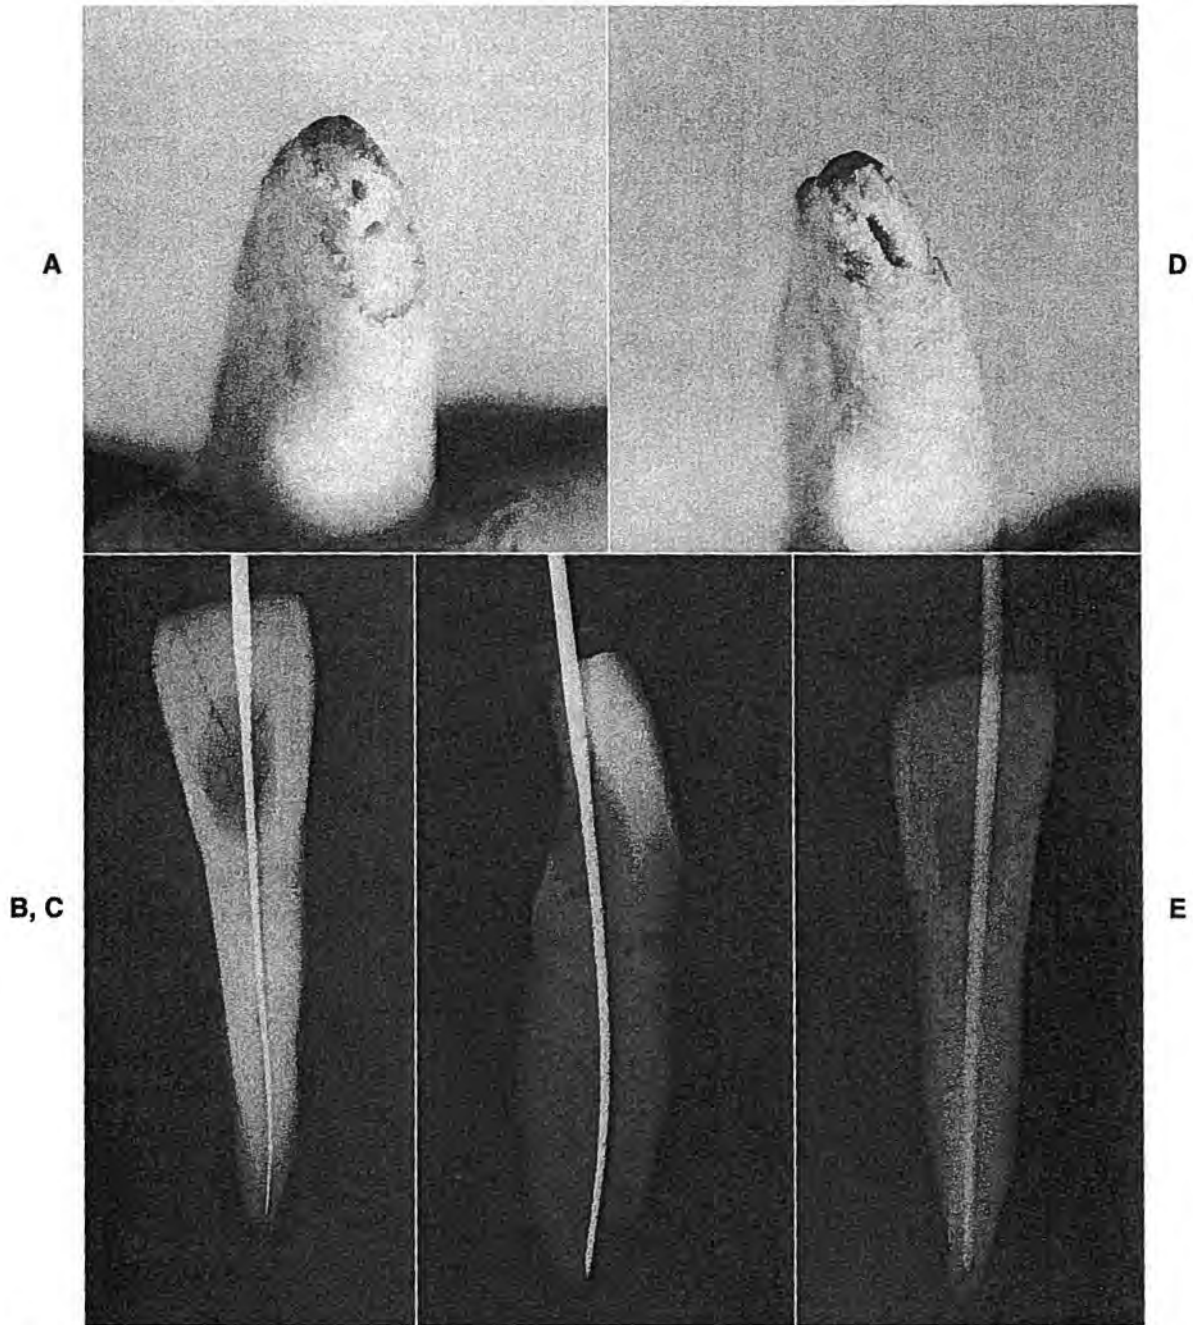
Zipped, teardrop shaped mandibular incisor after preparation through apex. A, Apical view of mandibular incisor root with canal exiting short of apex to the buccal. This is a tooth that typically will be overinstrumented. B, Radiograph of file in place seems to be well within confines of the tooth. C, Profile radiograph of labiolingual view, never seen with normal projection. Canal will be overinstrumented at a length that might seem satisfactory. D, Apical view after canal enlargement to size 35 at length indicated in C. This canal would be difficult to seal. E, Master gutta-percha cone size 35 appears to be approximately 0.5 mm too short. In fact, it was at least 0.5 mm too long.
